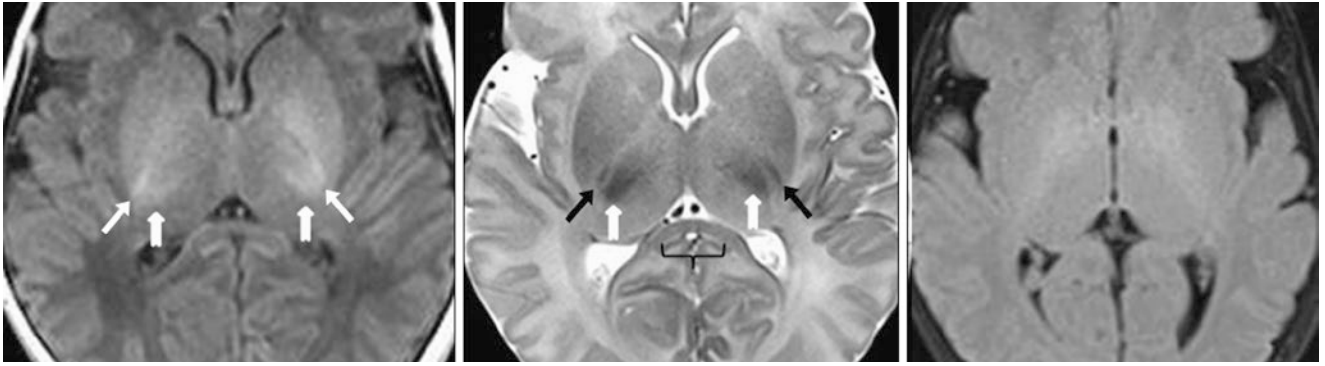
A 1-day-old term neonate had a normal 3T MRI with GE T1WI (left), SE T2WI (middle), and 2D FLAIR (right). The PLIC (arrows) is well visualized on both GE T1WI and T2WI, but not on
